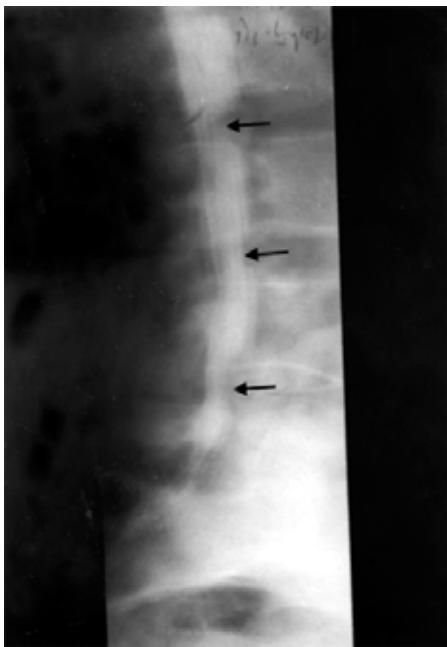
CT myelography. It shows multiple levels of indentations (↑) due to multiple disc prolapse
